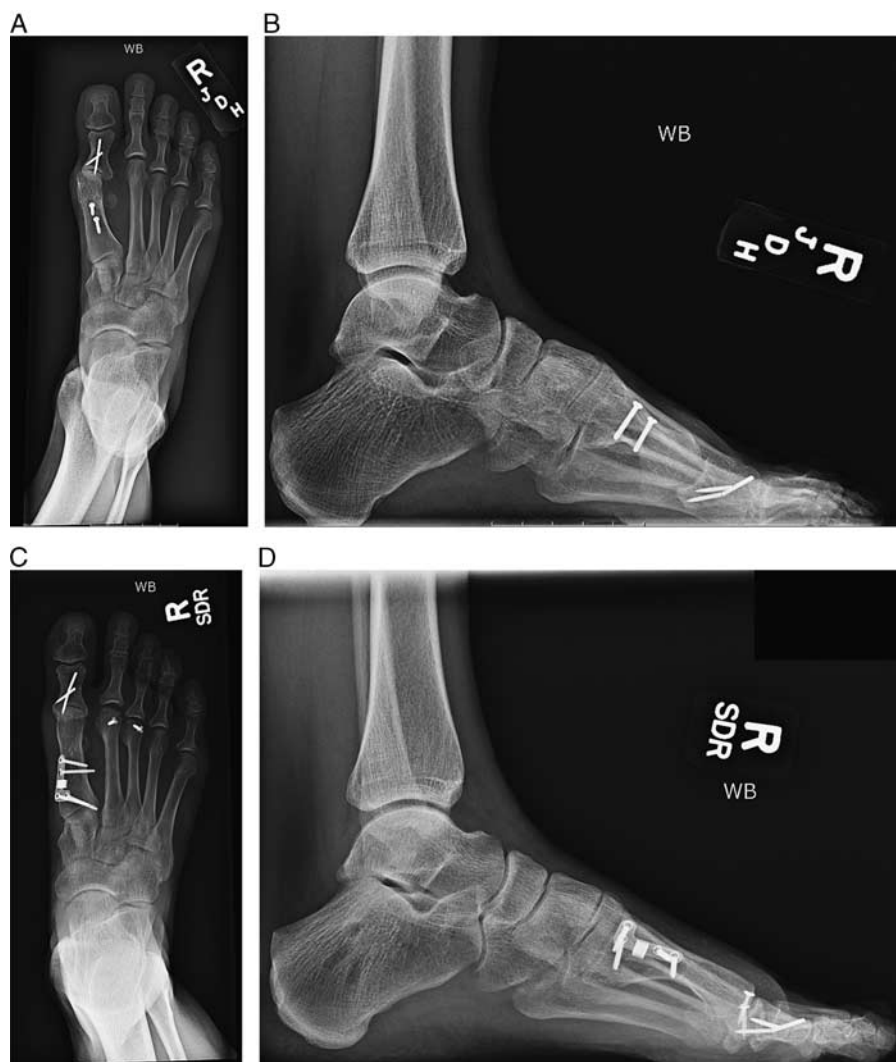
A and B, Anteroposterior and lateral preoperative radiographs show a previously failed scarf shaft osteotomy with a shortened and plantarflexed first ray. The patient has 21.5 degrees hallux valgus angle and 14.0 degrees intermetatarsal angle as a residual deformity with transfer metatarsalgia. C and D, Anteroposterior and lateral postoperative radiographs show postoperative correction of intermetatarsal angle and residual hallux valgus angle: 5.1 degrees intermetatarsal angle and 6.4 degrees hallux valgus angle. We felt this patient was an ideal candidate for the proximal opening wedge osteotomy given that we could gain length to her first metatarsal to combat her transfer metatarsalgia and improve alignment. At 1-year postsurgery, the patient remains very happy with her outcome.
